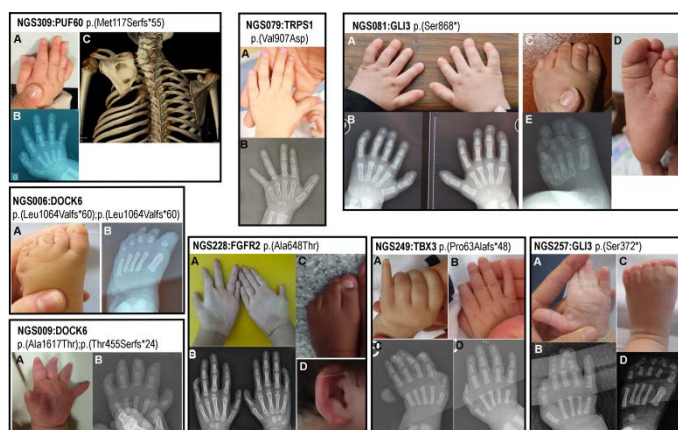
Pictures and radiographs of selected patients affected with congenital limb malformations.
